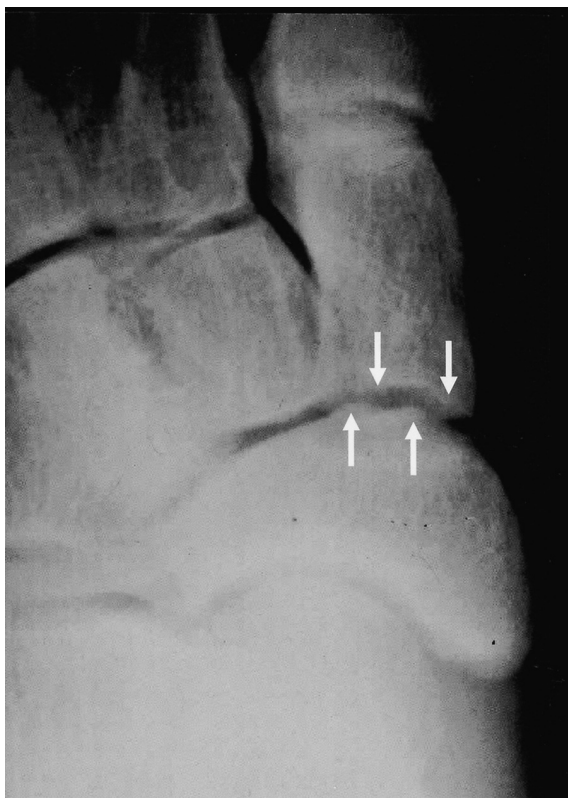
17-year-old female judo player with a painful naviculo-medial cuneiform coalition in her right foot. Anteroposterior radiograph shows an irregular articular surface of the naviculocuneiform joint (arrows). The joint space appears to be maintained.
